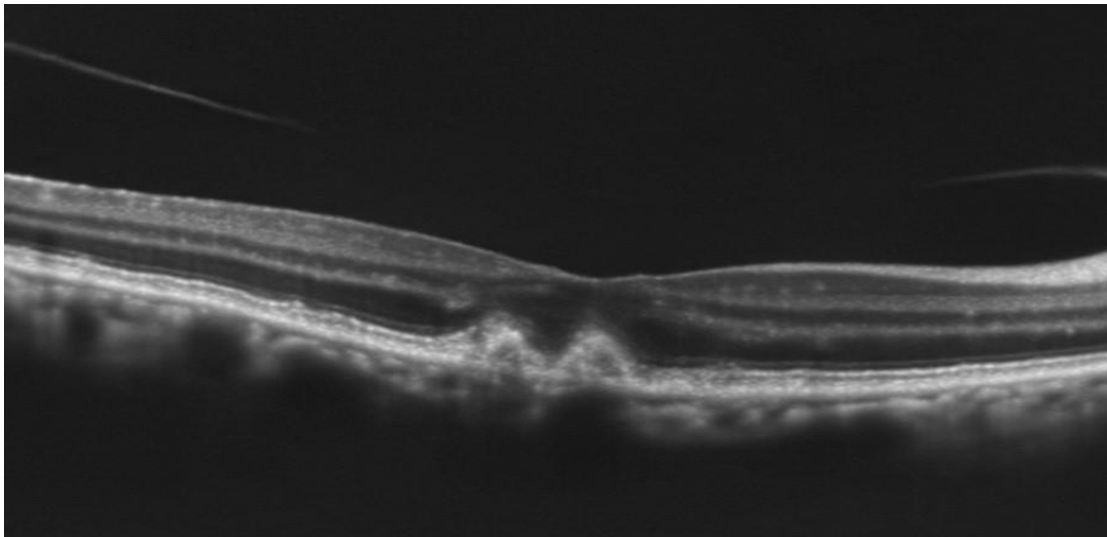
Geographic atrophy-CT view, lack of photo-receptors and atrophy of retinal layers in the macula
